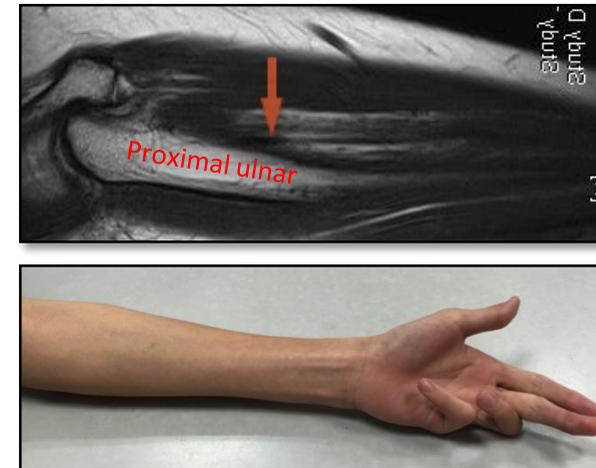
A 20-year old man with mild Volkmann's contracture of the left hand. MRI shows the pathological structure originate from the proximal ulnar.
